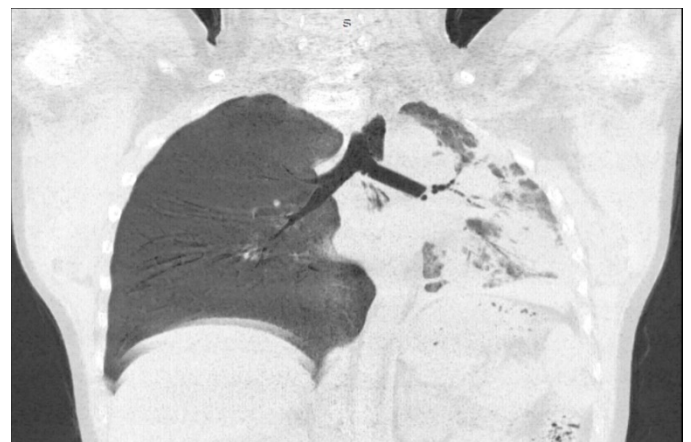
Figure b: CT – Thorax shows Collapse of left upper and lower lobes.
